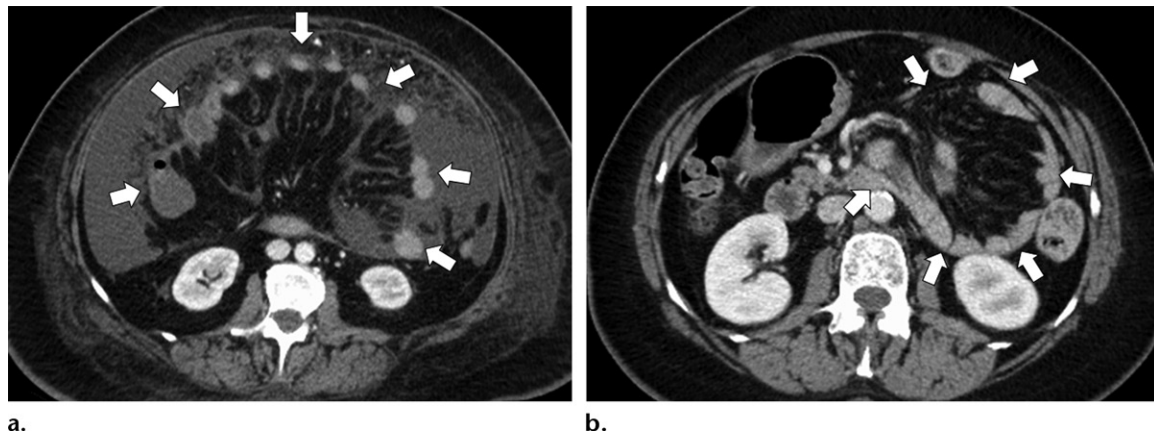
Mimics of EPS in two different patients. (a) Axial CT image of a 61-year-old woman with known peritoneal carcinomatosis secondary to an ovarian malignancy shows a characteristic centrally clustered arrangement of small-bowel loops in a cauliflower-like pattern (arrows). Confluent omental caking is demonstrated, a finding in keeping with carcinomatosis, but no thickened enhancing peritoneal membrane is depicted encasing the small-bowel loops, which would be seen in EPS. (b) Axial CT image of a 63-year-old woman with a nonobstructed left paraduodenal hernia (internal hernia) shows a characteristic clustered arrangement of small-bowel loops (arrows) in a paramidline location posterior to the inferior mesenteric vein. No thickened enhancing peritoneal membrane encases the small-bowel loops, which would be seen in EPS. The findings at surgery helped confirm the internal hernia.
